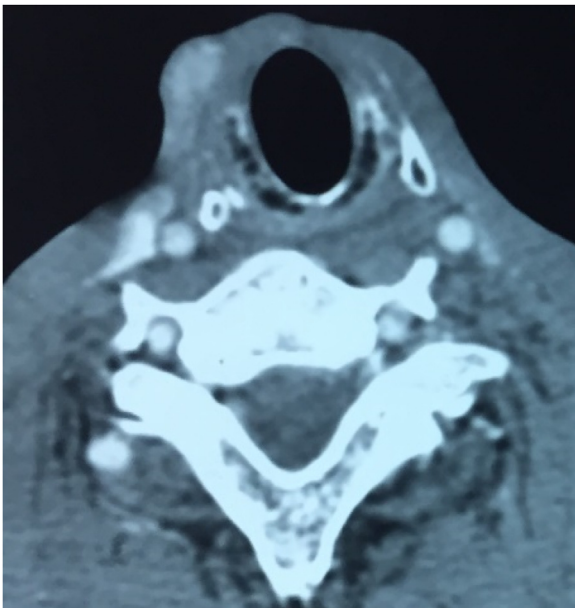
CT showing multiple heterogeneous round lesions.
